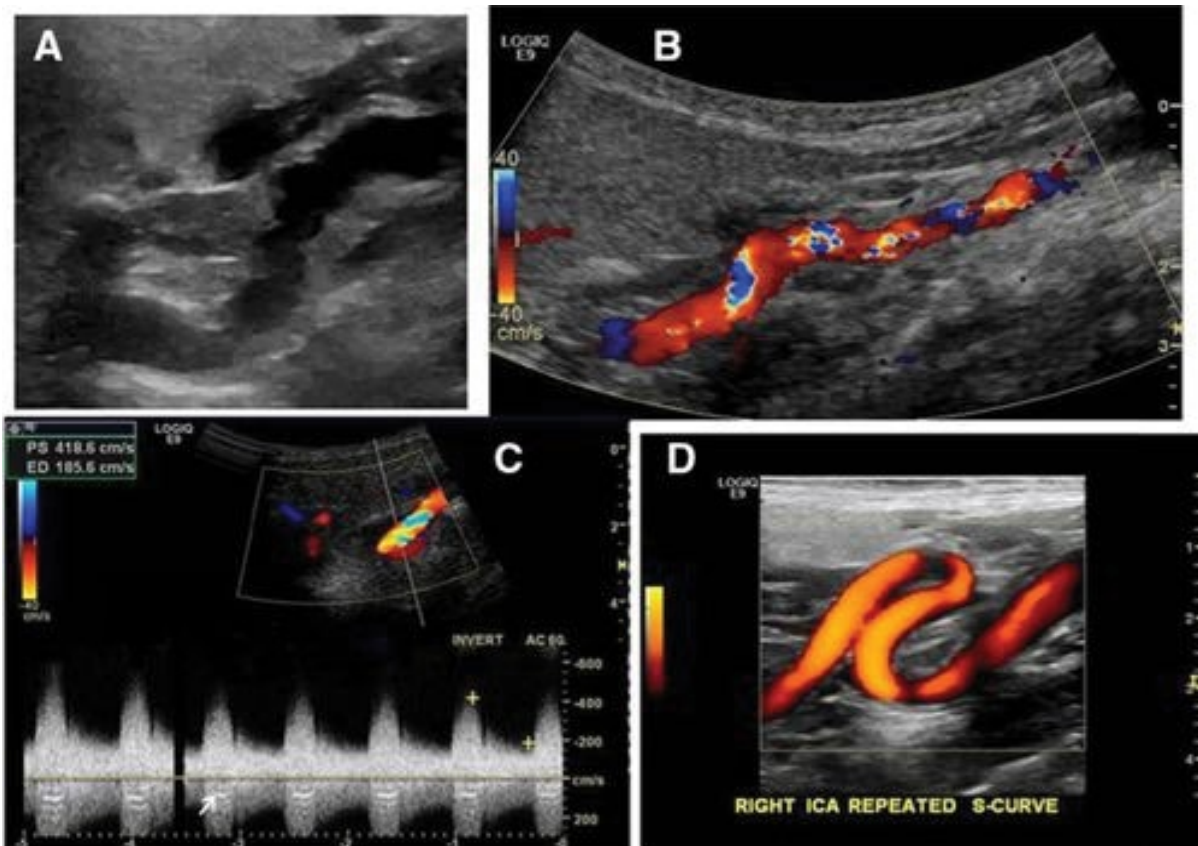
C demonstrates the spectral Doppler waveform in the stenosed internal carotid artery [10]. PSV is around 400 cm/s with evident spectral broadening due to the turbulent flow [10]. A demonstrates signs of beading and tortuosity in the mid to distal segment of the internal carotid artery [10]; B depicts colour Doppler aliasing, and D illuminates the tortuous S-shaped of the ICA using power Doppler [10].
